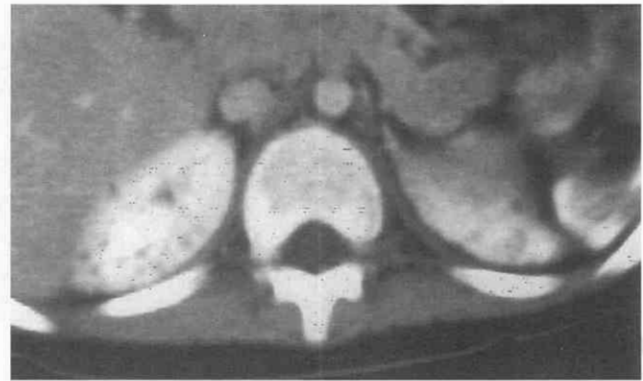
Autosomal dominant polycystic kidney disease in an asymptomatic 14-year-old boy whose father has the disease. A contrast-enhanced CT scan shows multiple, tiny bilateral renal cysts.
